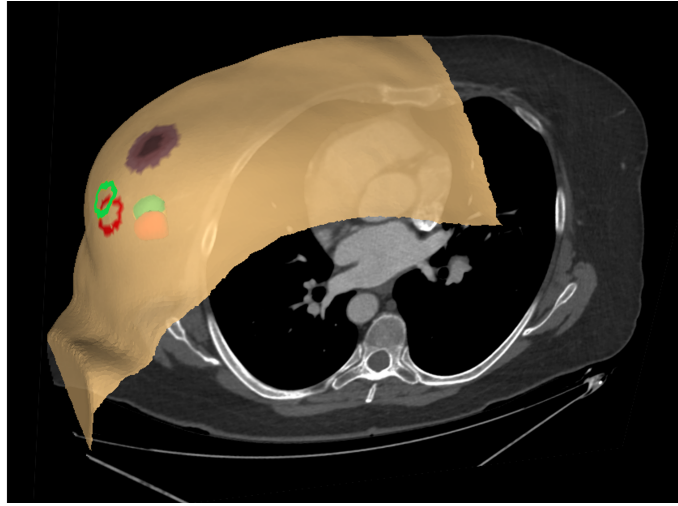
CT image and supine surface with skin projections of the estimated (red) and real (green) tumor centroid.
